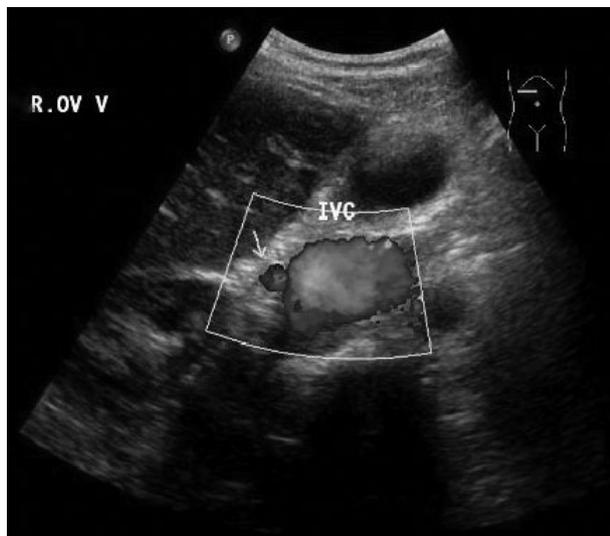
Pelvic duplex ultrasound scan: Colour Doppler imaging demonstrates non-occlusive thrombus in the right ovarian vein.
